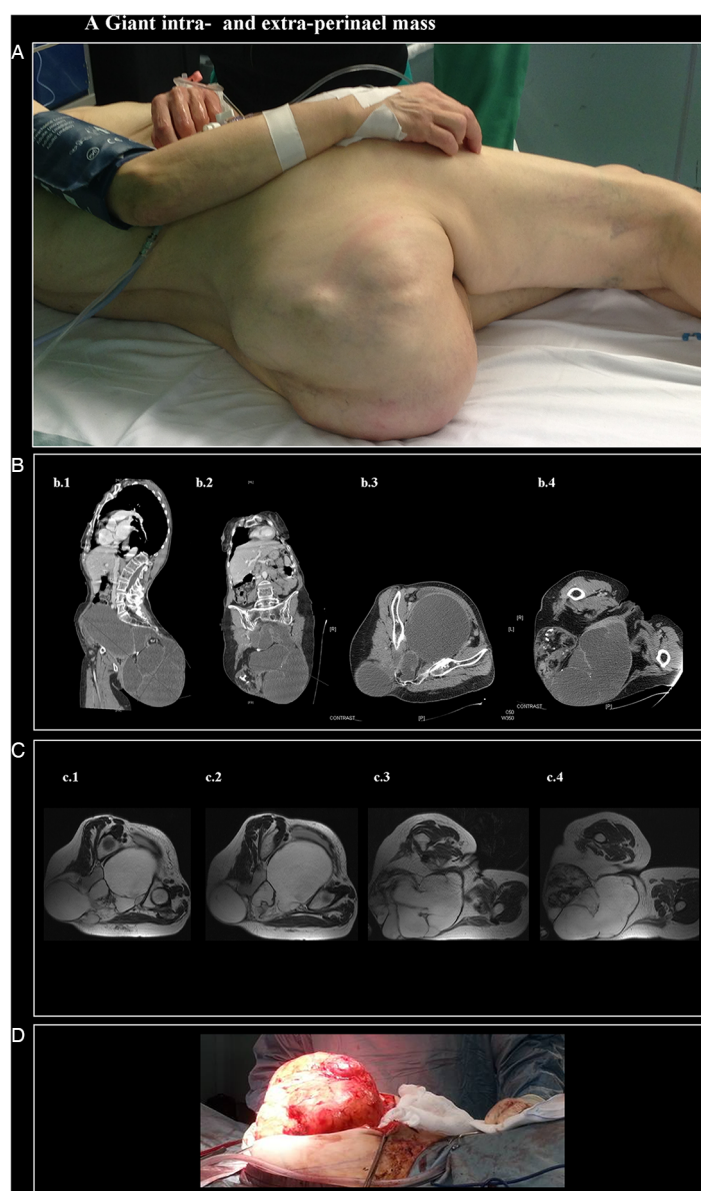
(A) Clinical appearance of the perineal mass protruding outside the perineum in the infragluteal space ('queen bee' shape). (B) Preoperative iodine contrast-enhanced CT scan documenting the tumour: (B1 and B2) CT sagittal and coronal multiplanar rendering views: in the CT reformation images both intrapelvic and extraperineal components of the mass are shown; CT axial images: (B3) pelvic involvement and superior aspect of the extraperineal mass; (B4) axial plane at the level of the proximal third of the thighs documenting the maximum diameter of the extraperineal component. (C) MRI: turbo spin-echo T2-weighted axial images at different levels; (C1 and C2) intrapelvic extension of the mass in the retroperitoneal space and in the posterior sacral region; (C3 and C4) perineal and intraperineal major cystic component close to the left para-sagittal plain, adjacent to the proximal left thigh. (D) Posterior surgical approach to the tumour.
